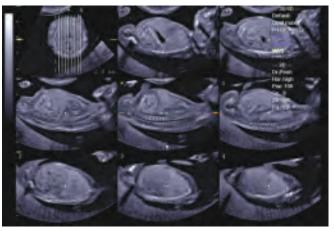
Tomographic ultrasound imaging of normal thoracoabdominal structure at 13 weeks of gestation. Parallel sagittal sections are shown. Lung-liver border and intraabdominal organs are clearly visualized
